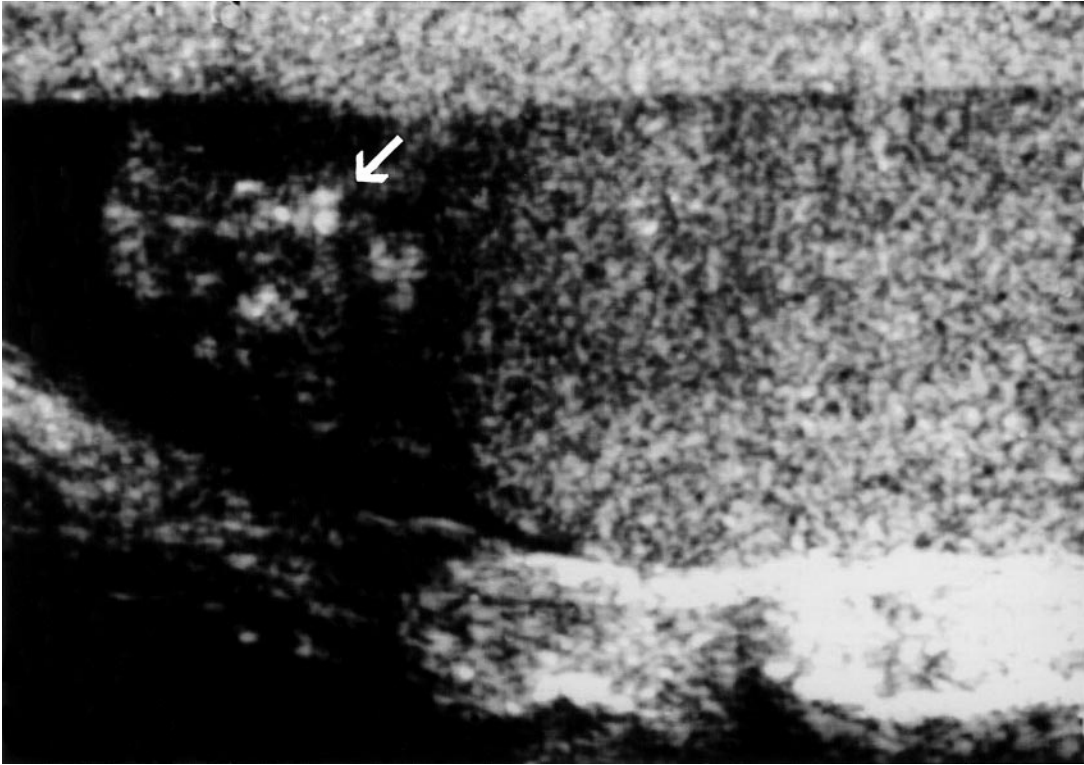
Longitudinal ultrasound examination shows multiple echogenic foci of the head of the epididymis.
